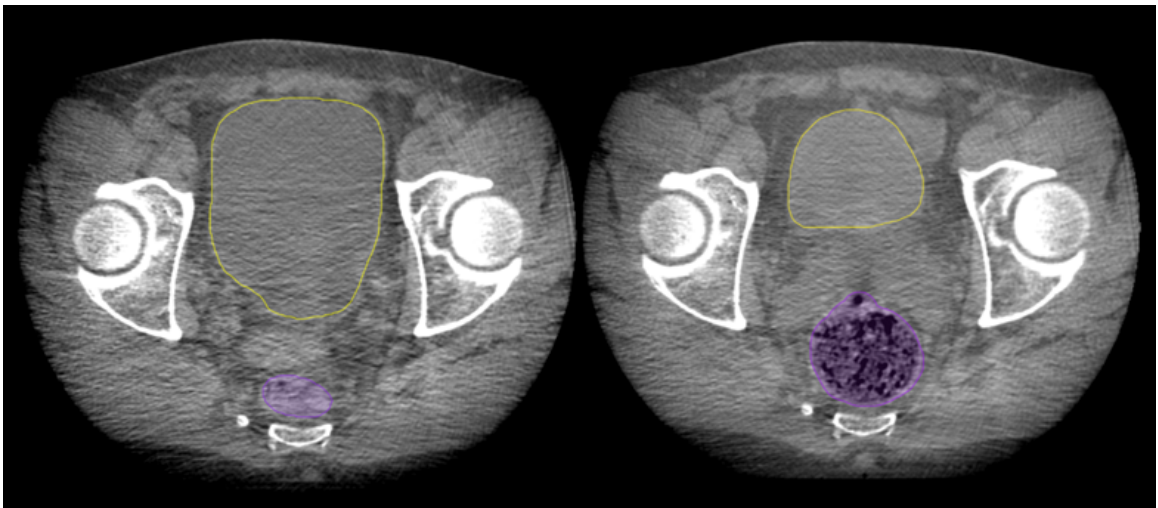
Example of inter-fraction variation of the rectum and bladder in prostate radiotherapy. Images are CBCTs from a single patient’s third and fourth fractions.
